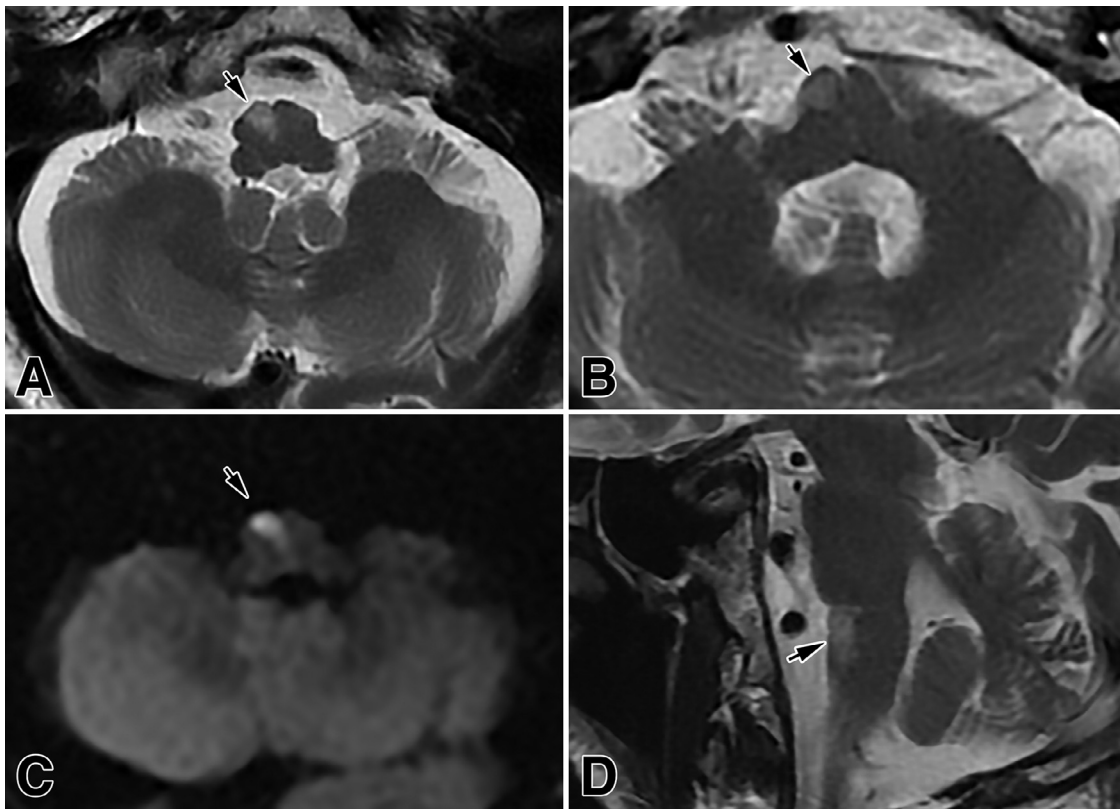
A right incomplete medial and anterolateral infarction (arrows) of the upper medulla, extending to the pontine border. It is presented in the axial T2-weighted (A and B) and DWI (C) images, and in a T2-weighted sagittal section (D).
